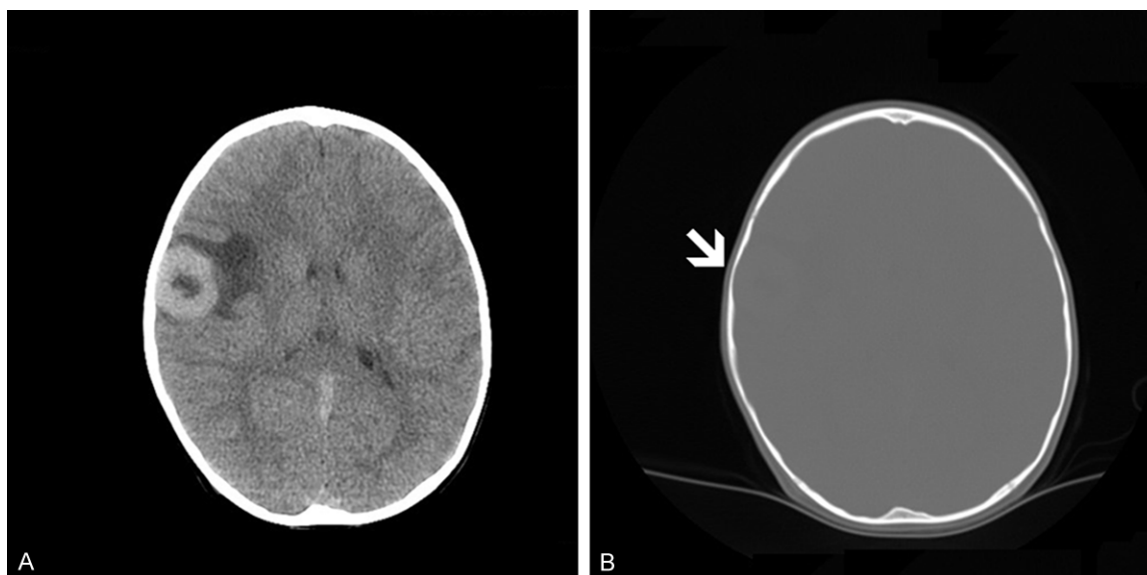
CT image of Case 1 demonstrates a round lesion with peritumoral vasogenic edema (A). Remodeling of the bone overlying the tumor is also noted (B).
